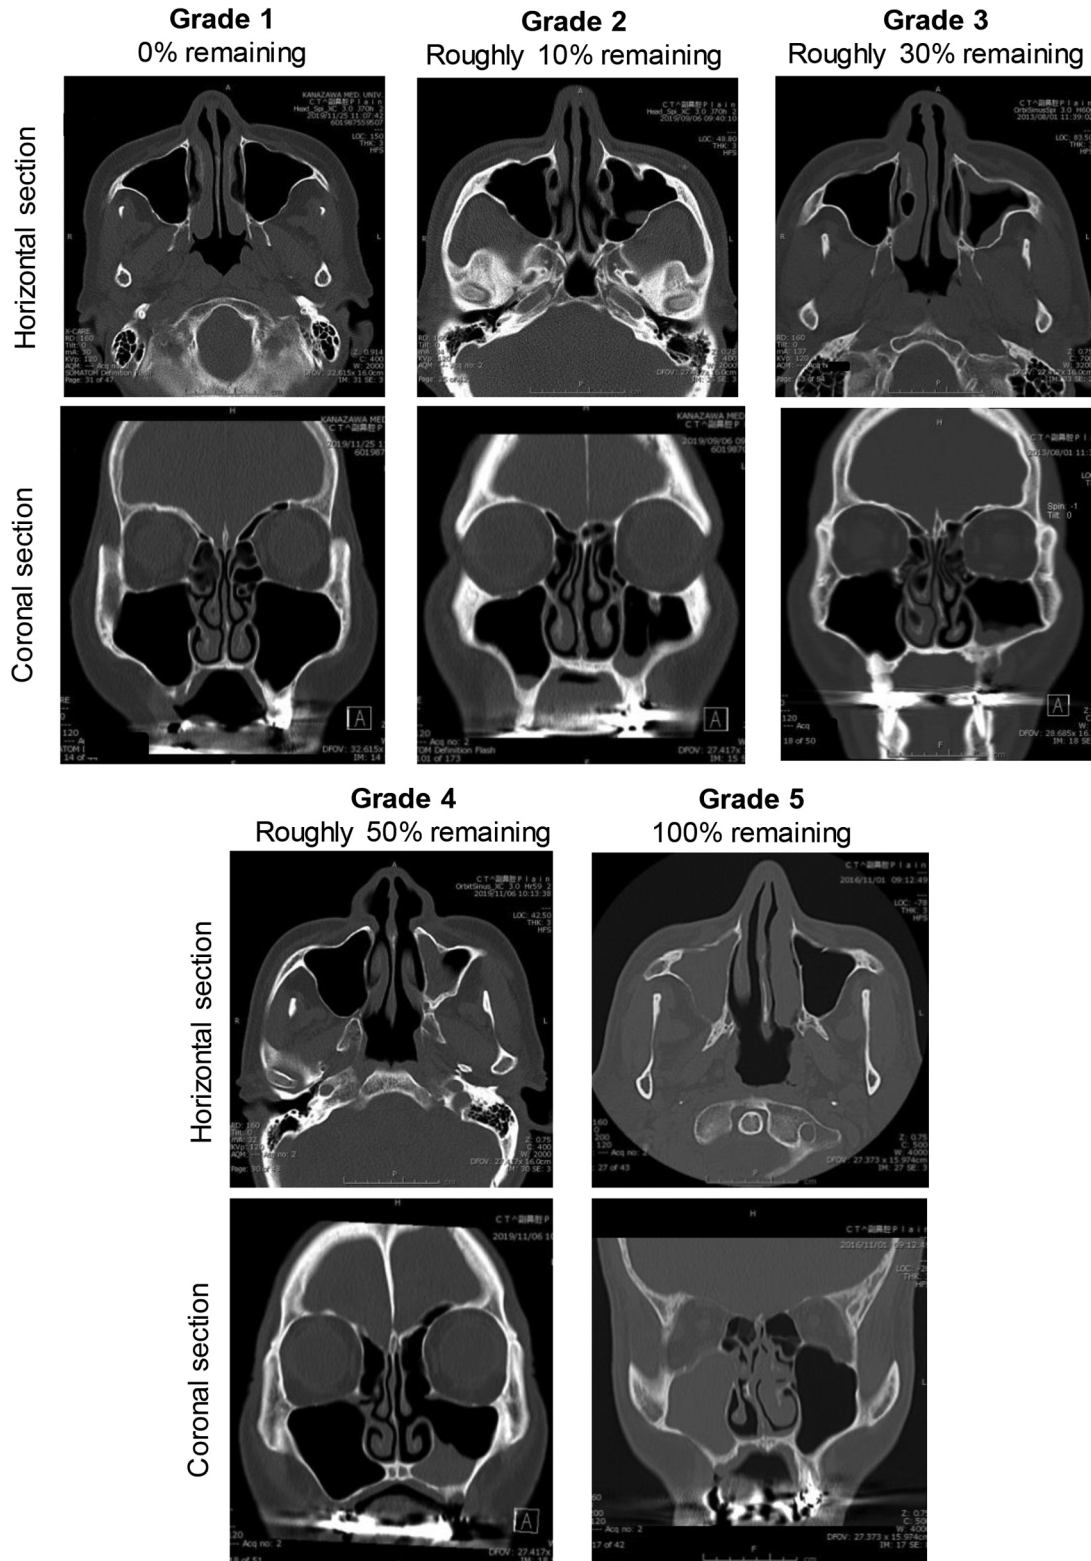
Computed tomography images of the therapeutic efficacy of tooth extraction and irrigation for odontogenic maxillary sinusitis (OMS). Depending upon the extent of remaining of maxillary sinus mucosal lesions, therapeutic effect was scored as Grade 1 (0% remaining mucosal thickening, disappearance of lesions), Grade 2 (roughly 10% remaining), Grade 3 (roughly 30% remaining), Grade 4 (roughly 50% remaining) and Grade 5 (100% remaining, no improvement), respectively. Upper panel: horizontal section; Lower panel: coronal section.
